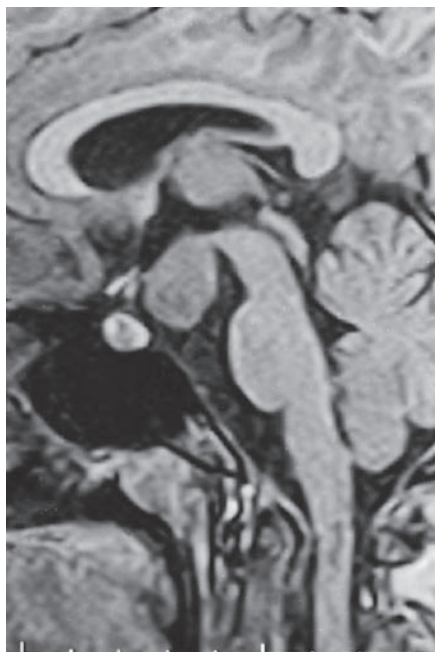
MRI in sagittal plane (SPGR imaging sequence) showing a well-defined isointense mass in the region of tuber cinerium, distinctly separate from the pituitary gland and infundibular stalk.
